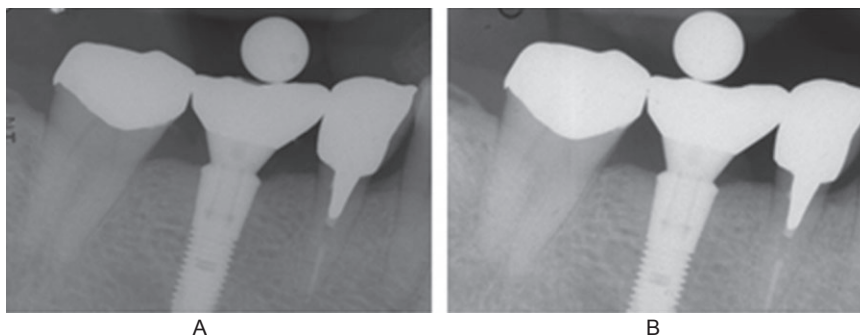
Periapical radiographs taken (A) immediately after and (B) 6 years after prosthesis delivery.
